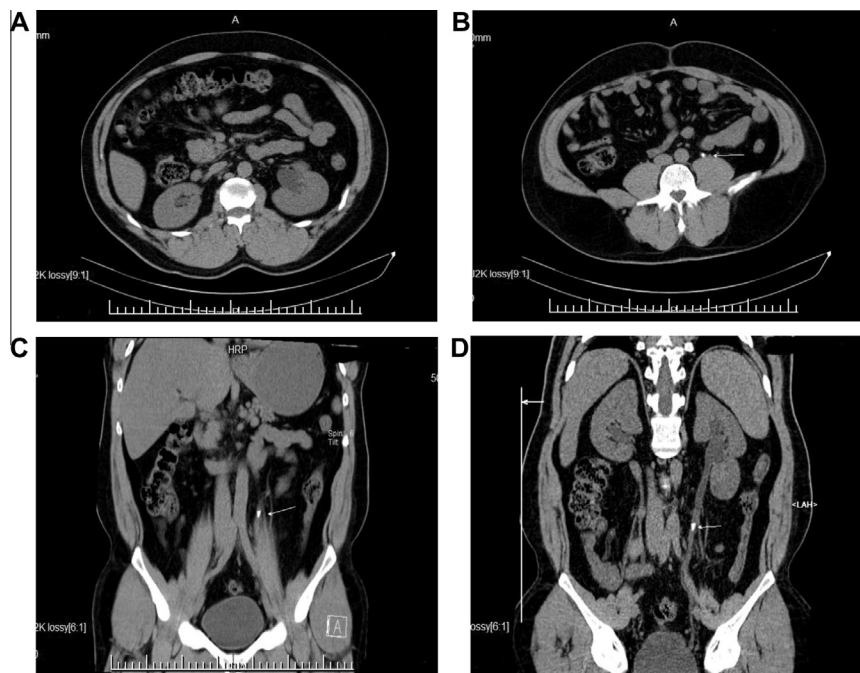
(A–D) 50-year-old male with acute left loin pain. Axial (A and B) Coronal (C and D) CT reformation of MDCT scan shows mild left-sided pelviectasis (*arrowhead*). Dilated ureter can be traced to 4-mm obstructing calculus (*arrow*).
